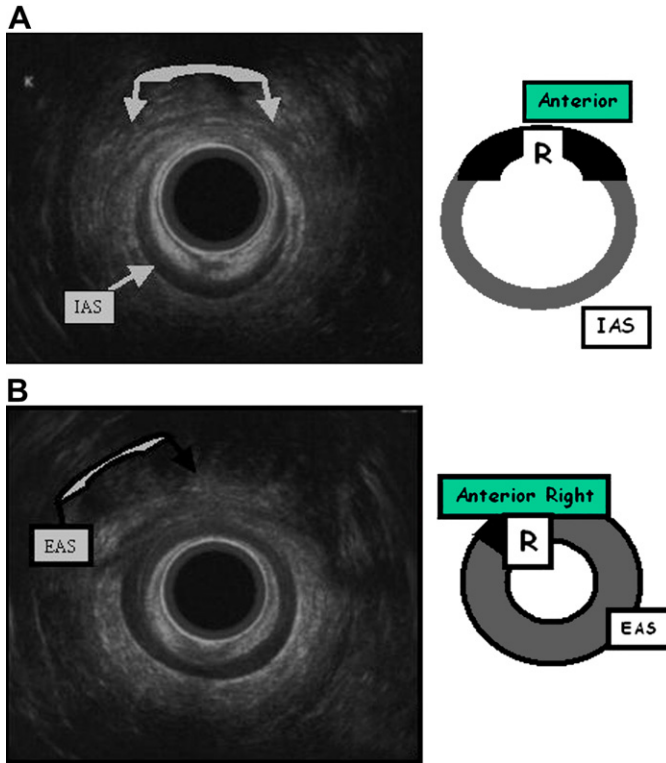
Anal endosonography showing an anterior sphincter defect. (A) IAS defect with a posterior retraction of both ends. (B) EAS defect.
